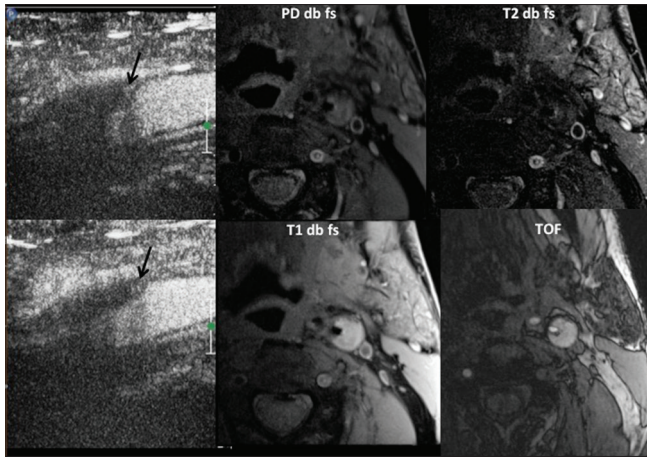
A 71-year-old male with left middle cerebral artery stroke. Left internal carotid artery 80% stenosis. On contrast-enhanced ultrasound, moving microbubbles are seen on the shoulder of the plaque. On magnetic resonance imaging plaque imaging, it appears isointense on proton density, hypointense on T2-weighted with small hyperintense component, and hyperintense on T1-weighted and time-of-flight s/o fibrofatty plaque with a small hemorrhagic component. Surface ulceration is present
